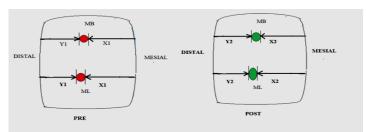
Representative CBCT coronal plane sample of a pre- and post-instrumentation depicting the measurement of mesial and distal dentin thicknesses according to Gambill et al using the equation: [(X1 - X2) - (Y1 - Y2)].
